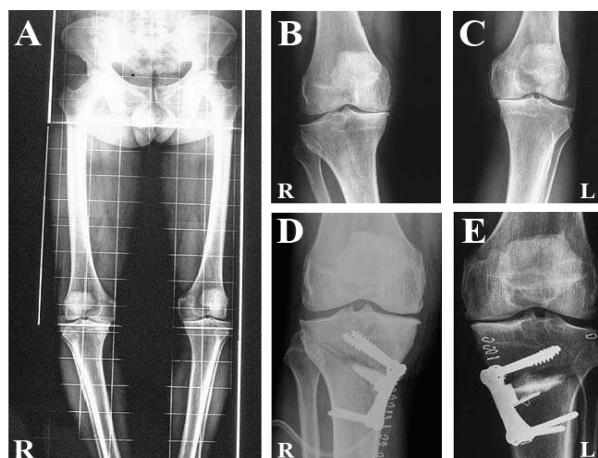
Radiographic examination. (A) Preoperative general X-ray; (B) Preoperative X-ray of the right leg showing a 10° anatomical varus; (C) Preoperative X-ray of the left leg showing a 6° anatomical varus; (D) Postoperative X-ray after 8 weeks of right knee treated with Bonelike[®] wedge; (E) Postoperative X-ray after 8 weeks of left knee treated with commercial HAp/β-TCP.
